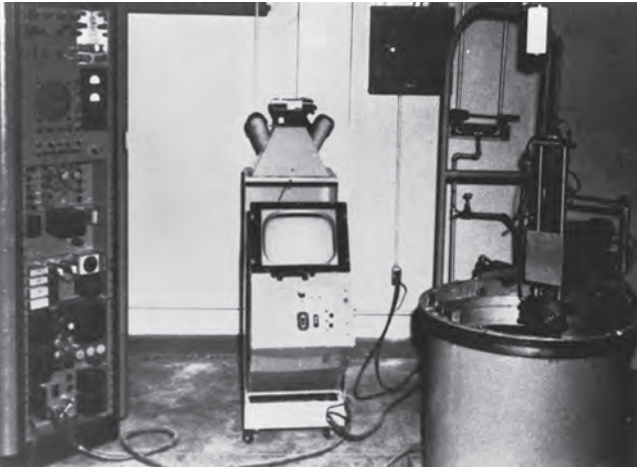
Douglass Howry, along with William Roderic Bliss and Gerald J. Posakony, both engineers, produced the "immersion tank ultrasound system," the first two-dimensional B-mode (or plan position indicator mode) linear compound scanner.
